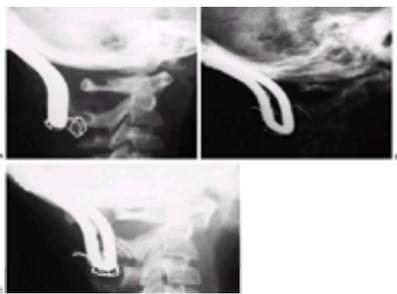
A: The child in Figure 21-2 underwent posterior cervical fusion from the occiput to C2 with internal fixation and an autogenous iliac crest bone graft. B and C: Halo vest immobilization was maintained for 4 months postoperatively, and was followed by a Philadelphia collar. Despite this the boy progressed to nonunion, as indicated by graft resorption, wire breakage, and subsidence of the Luque rectangle, although flexion and extension radiographs 1.5 years postoperatively showed a marked decrease in hypermobility. The atlantooccipital distance was 4 mm, with only a 1-mm change of the atlanto-dens interval; the space available for the cord measured 18 mm in flexion and 19 mm in extension. The child's neurologic symptoms also disappeared.
